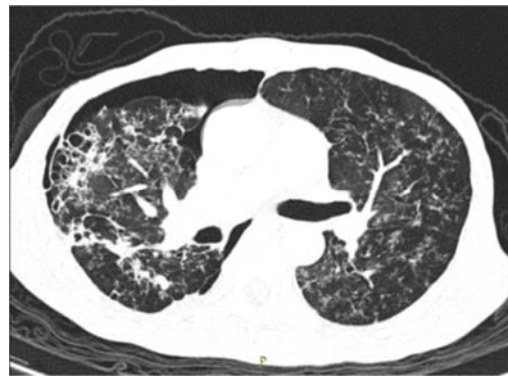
CT thorax imaging shows tree-in-bud appearance over bilateral lung field with right pneumothorax.
